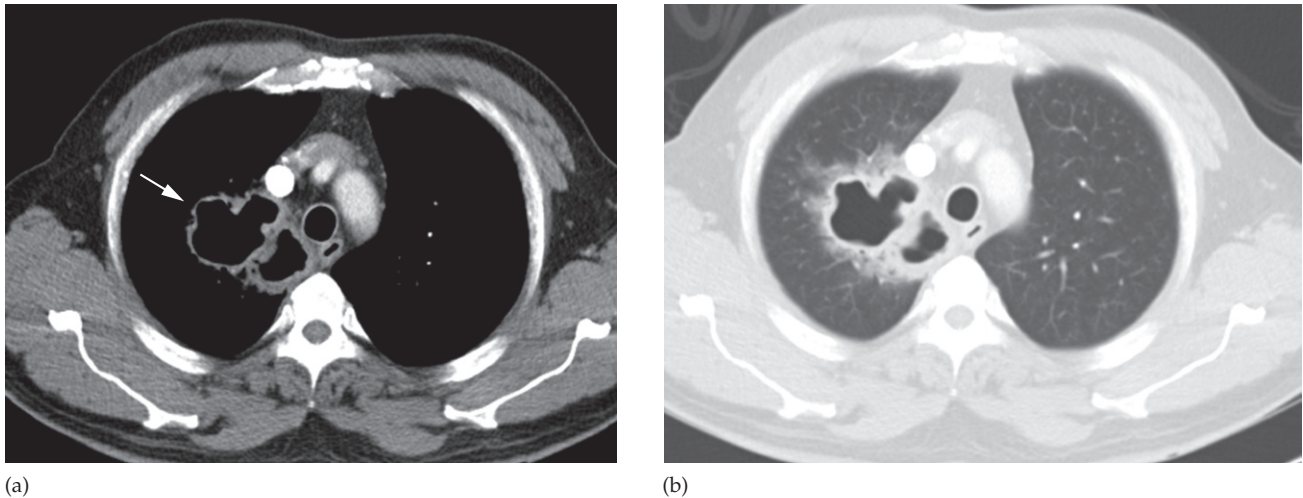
Bacterial lung abscess shown by CT on (a) mediastinal and (b) lung windows. Note the thick-walled, air-filled cavity. The abscess is arrowed in (a).
